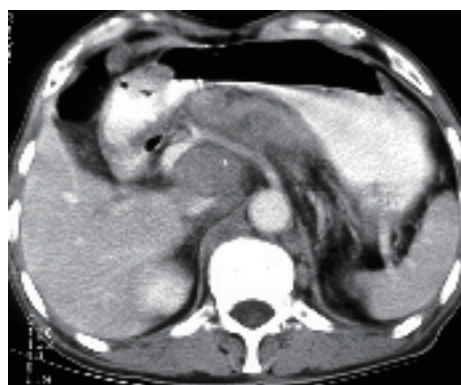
Multiple-nodular type: CT of portal venous phase showing mesenteric multiple enlarged lymph nodes with superior mesenteric artery encased.
